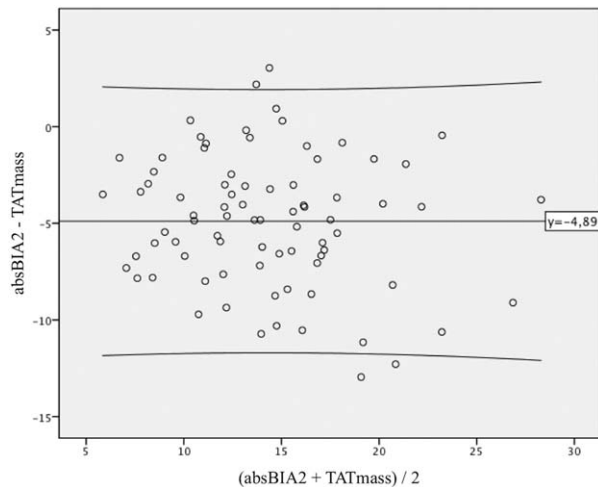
Bland-Altman plot of difference versus mean of impedance (absBIA2) and MR (TAT) based total fat-tissue mass assessments (TAT<sub>mass</sub> (unit: kg)). Total body fat estimation by impedance was measured with a handheld device (see M&M). The AbsBIA2 significantly underestimated the total fat mass as determined with the fat-water-separated MRI, showing a mean bias of approximately 5 kg. However, because we excluded arms and lower legs from the MR-based analyses, the mean bias of impedance fat mass quantification might be even greater than determined in our study.
